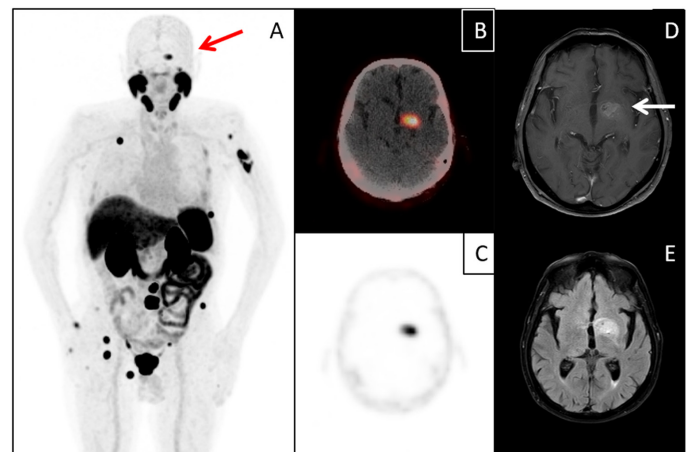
The whole-body ⁶⁸Ga-PSMA PET/CT images (A) show intense PSMA uptake in brain metastasis, indicated by the red arrow. Fusion PET/CT and PET images highlight a slightly hypodense lesion demonstrating intense PSMA uptake at the level of the left basal ganglion (B, C). Concurrent T1 MRI images reveal a contrast-enhanced lesion (D—white arrow). At 6 months without treatment (E), FLAIR images show an increase in lesion (hyperintense) size and midline shift. MRI, magnetic resonance imaging; PSMA PET/CT, prostate-specific membrane antigen positron emission tomography/computed tomography.
